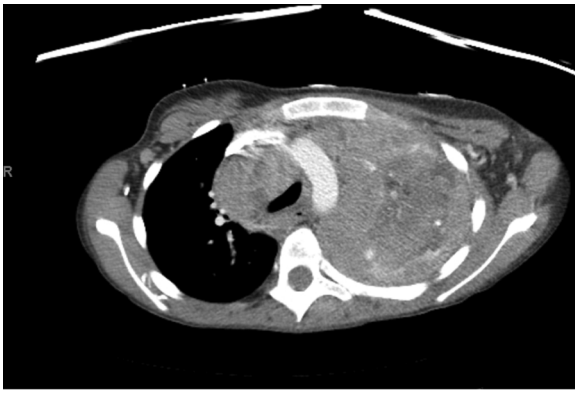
CT scan image of a pleural based mass of the left lung that is markedly thickened and nodular and encompasses the entire pleura.
